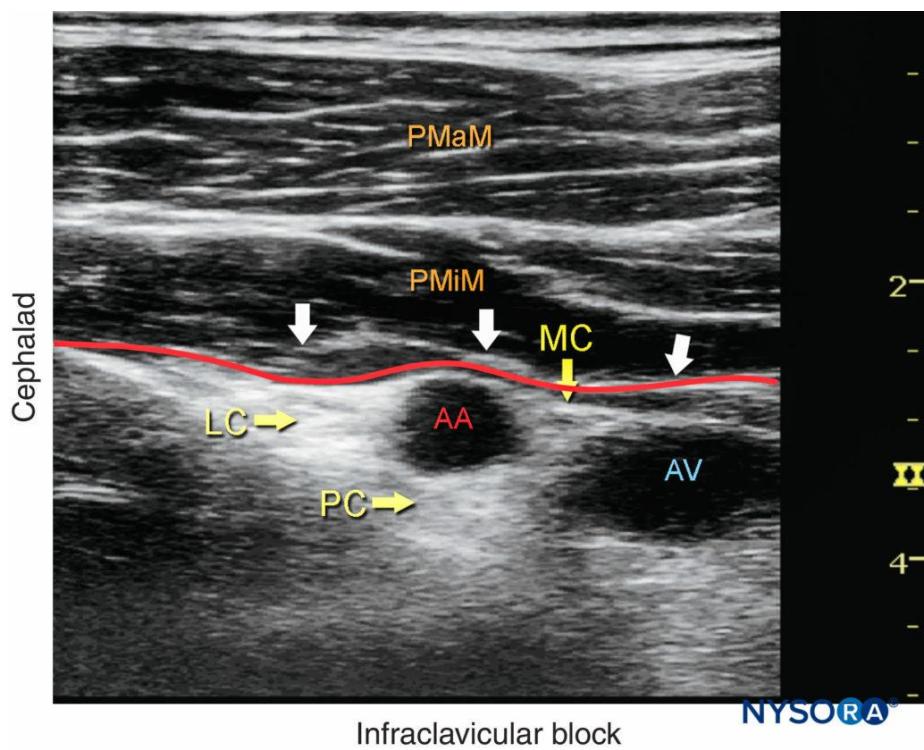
Ultrasound picture Of block
